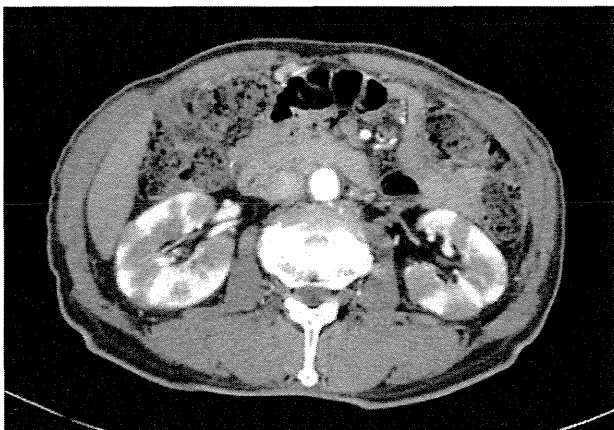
Representative enhanced CT scan in case 6 reveals multiple nodular lesions with frequent effacement in the bilateral kidneys. Note that the enhanced area includes both the cortex and medulla. Retroperitoneal fibrosis is also present.
